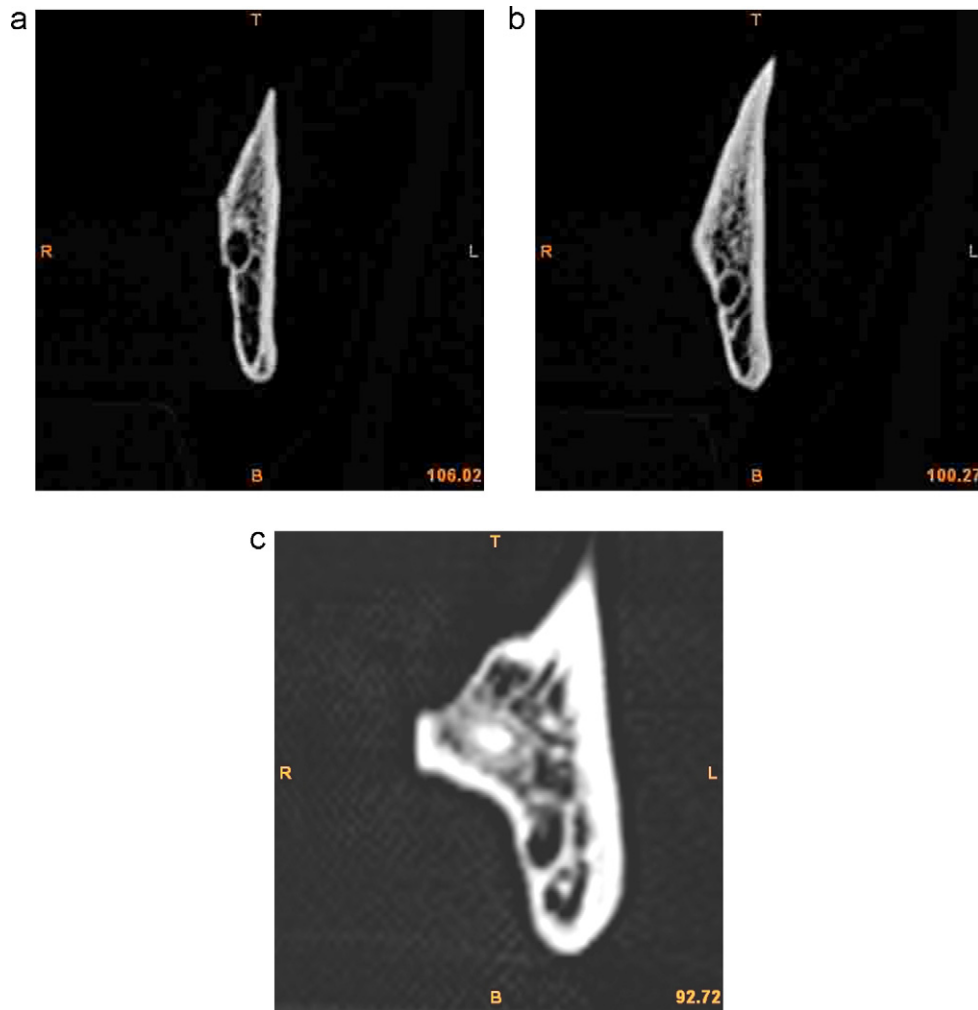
Coronal CT showing proximity only at the lingual cortex at positions (a) X1, (b) X2 and (c) X3.
